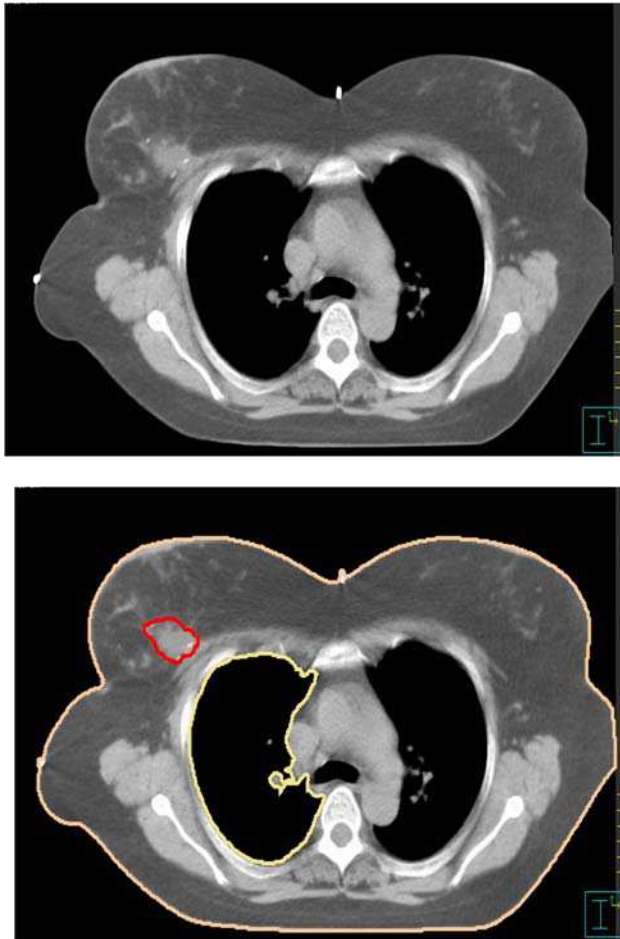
Breast cancer - (a) CT scan after breast conserving surgery before catheter implantation. Visible three clips, (b) the target (tumor bed) volume (red line), lung and skin (OARs) are outlined.
